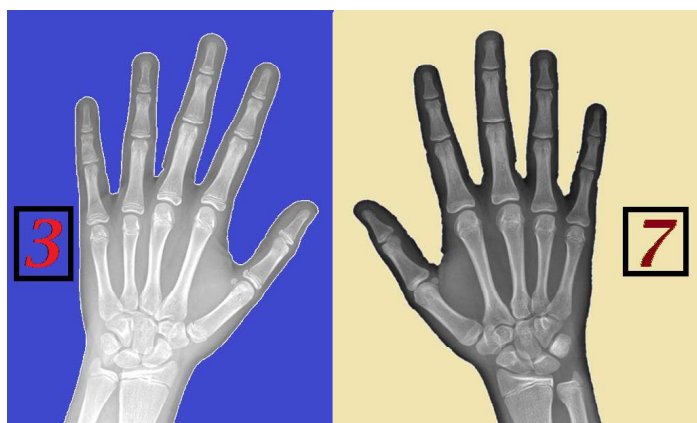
A hand x-ray corresponding to Sanders Stage 3 on the left and Stage 7 on the right. Note that in Stage 7, all physes are closed except for the distal radius physis, whereas the phalangeal and metacarpal physes are open in Stage 3.
